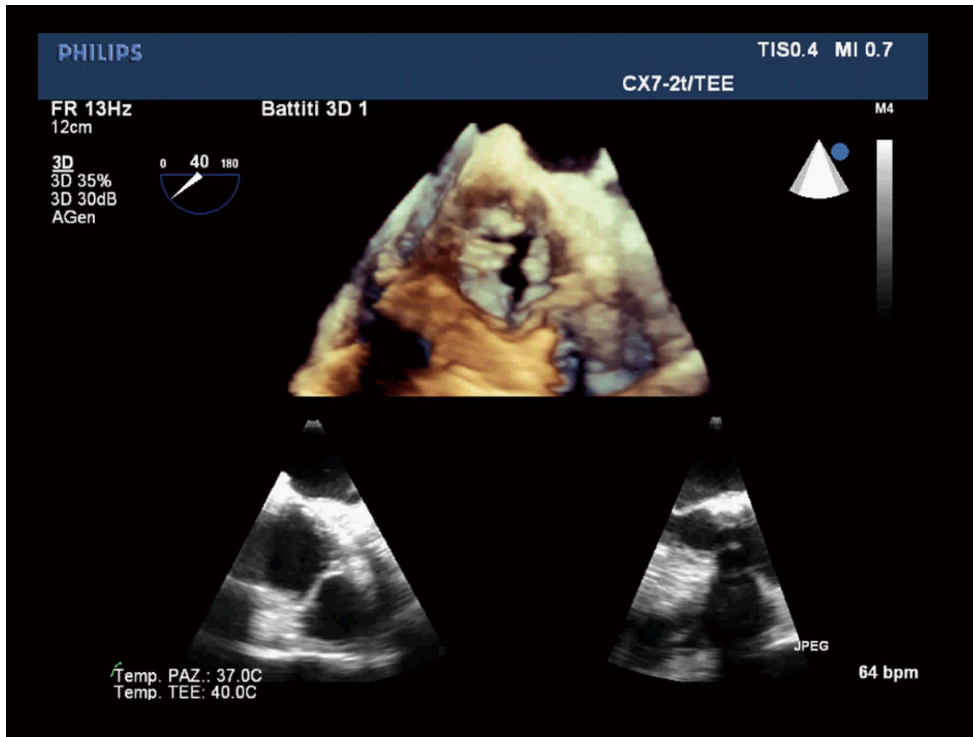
Three dimensional transesophageal echocardiography allows to visualize the real shape of left ventricular outflow tract, and has proved more effective in providing optimal annular measurement and was more useful in predicting paravalvular aortic regurgitation compared to 2D-transesophageal echocardiography.
